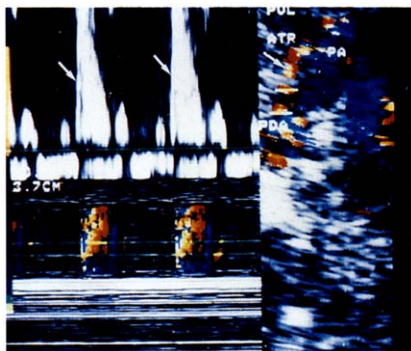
Doppler color flow echocardiogram in a 28 week old fetus with progressive development of pulmonary outflow obstruction that eventually progressed to pulmonary valve atresia (PVL ATR). Bidirectional flow is observed in the main pulmonary artery (PA), with retrograde flow (arrow) from the ductus arteriosus (PDA).
